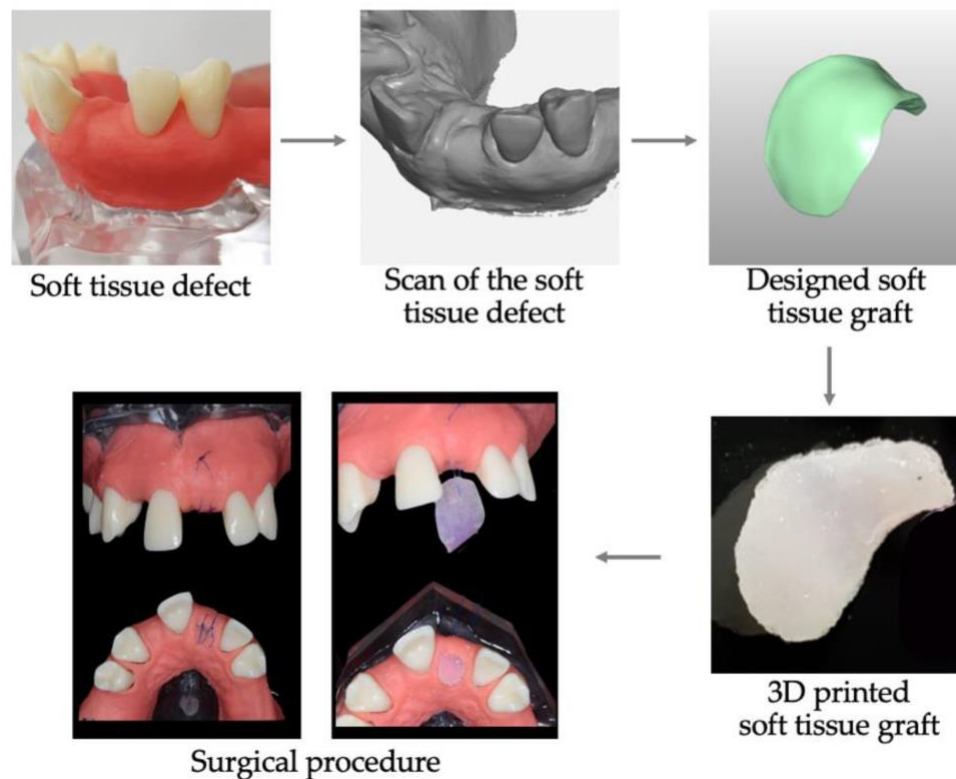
The Potential Protocol for Soft Tissue Grafting in The Future. This figure depicts a predicted method of intraoral soft tissue implantation using a 3D bioprinted artificial soft tissue graft. Starting with obtaining intraoral scans and CBCT imaging, following with CAD/CAM designing of the tissue graft, printing, and lastly with performing the surgical procedure (Obtained from Nestic et al., 2020).
